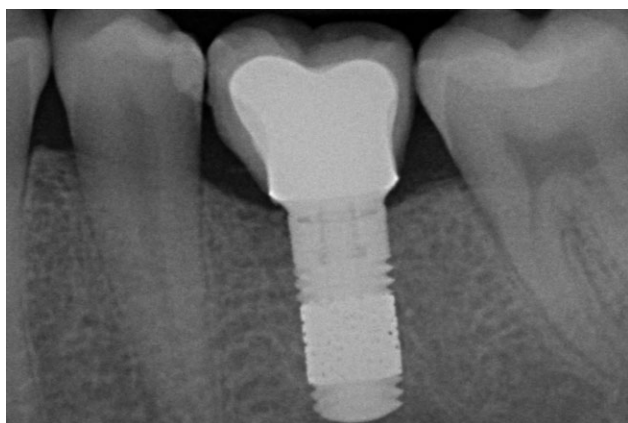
Postoperative (6 months): radiograph shows little or no change in marginal bone levels.
